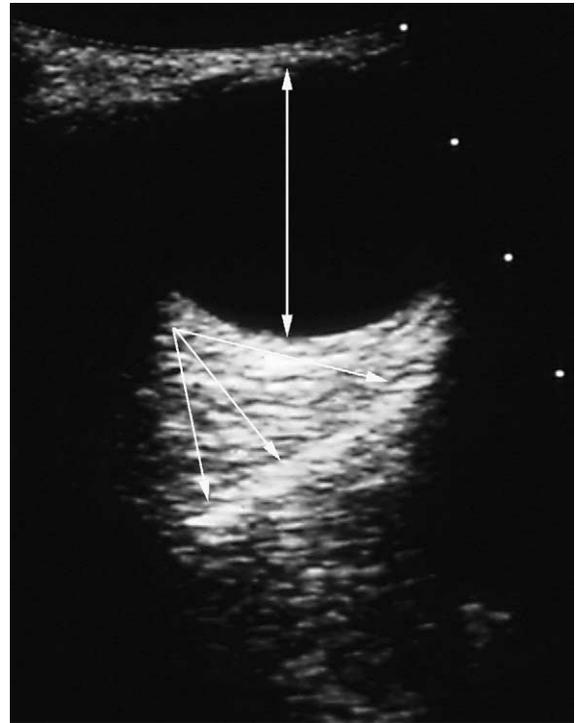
Ultrasound image of the normal anatomy of the orbital floor. The double arrow shows the globe. The three arrows show the convex structure of the orbital floor.
